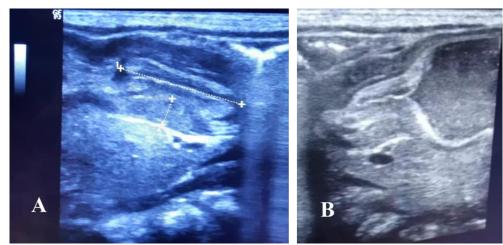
(A and B): Abdominal ultrasound in longitudinal section showing muscular thickening (A) with elongation and hypertrophic stenosis of the pyloric muscularis and gastric stasis (B)
